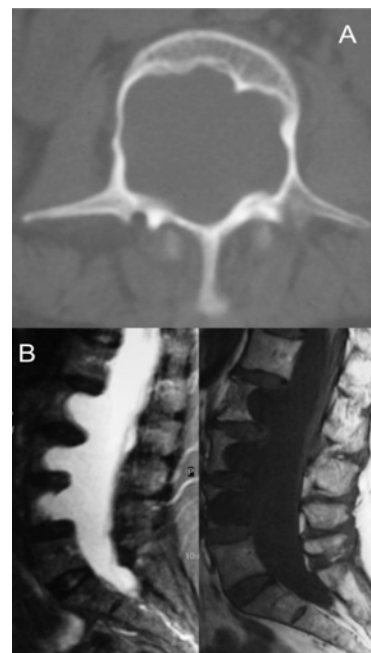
Absence of the posterior aspect of the vertebral bodies with an anterior meningocele confirmed by CT (a) and MRI (b).
